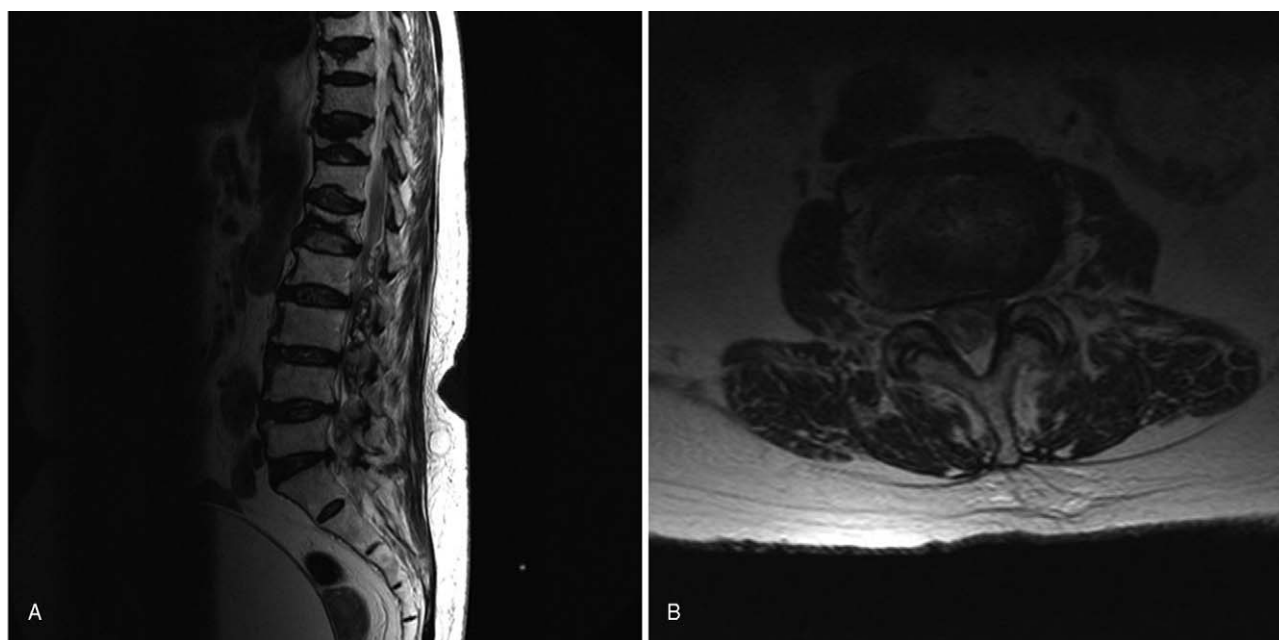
Magnetic resonance image one week after the PRF procedure shows (A) spinal epidural hematoma at L1 to L5 in sagittal T2-weighted image and (B) thecal sac compression by hematoma at the L3 to L4 level in the axial T2-weighted image.
